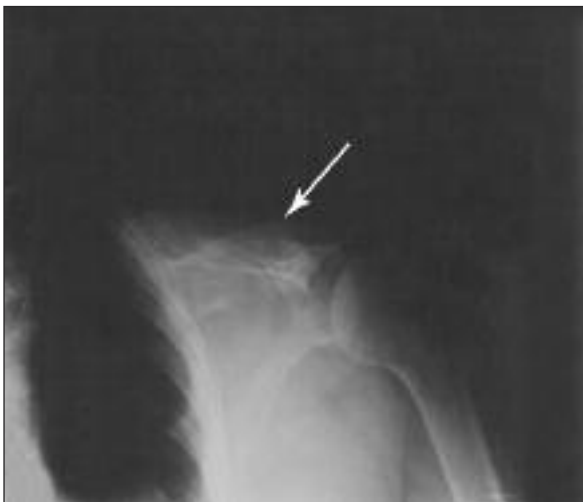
The PA chest x-ray revealed an increase in density with expansion, lysis and sclerosis in the left clavicle and medial region of the left scapula.
